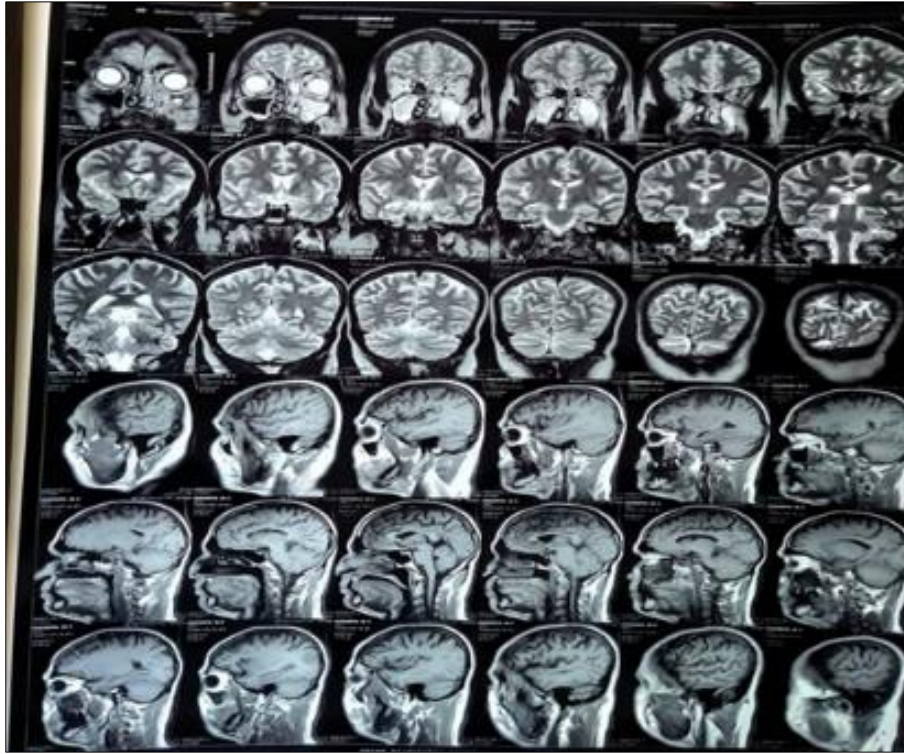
MRI Brain and Nose & PNS- a) Axial, b) Coronal & c) Sagittal sections
